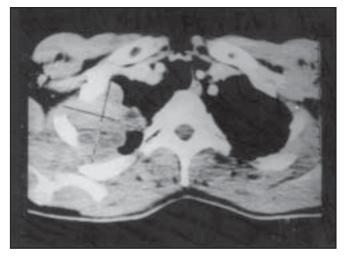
Axial CT section of chest shows a right paraspinal region mass with lobulated outline
